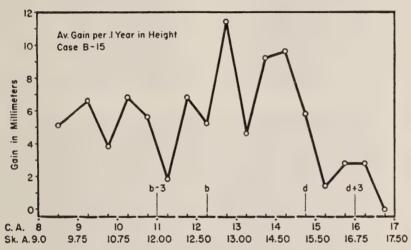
This figure shows the height growth profile for Case B15 whose X-ray photographs are shown in Figure 131b, and indicates the relation between skeletal age and chronological age at the developmental points for height.
